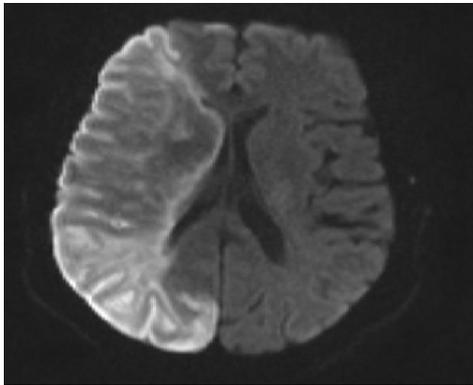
A T2 MRI brain (DWI sequence) of the patient in figure 1 few hours later demonstrating a bright signal in the complete right MCA territory indicating restriction of water movement that represents an acute ischemia (see figure 3).
